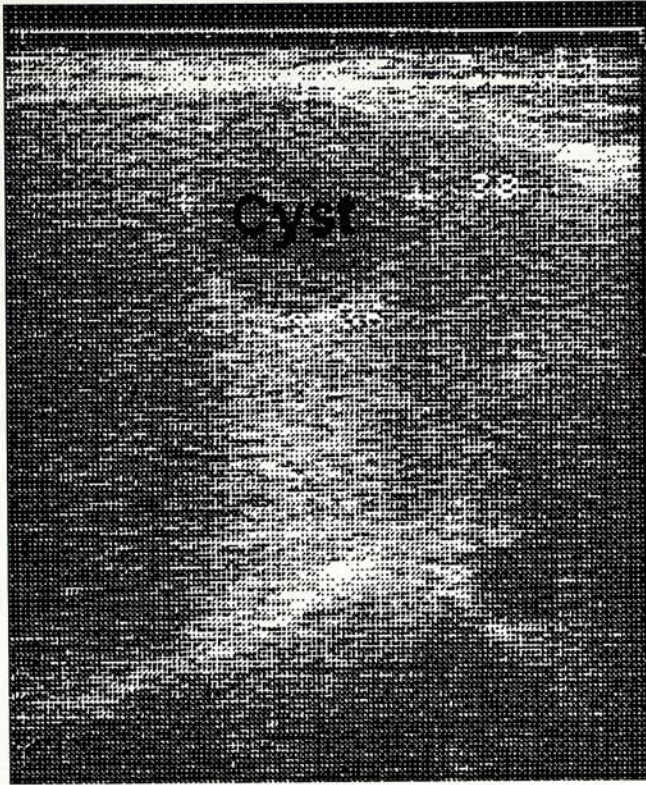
Ultrasound showing a liver cyst
